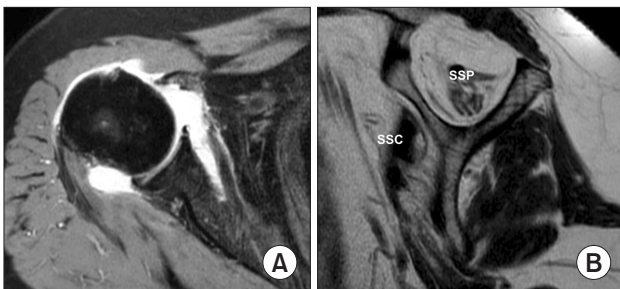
Preoperative magnetic resonance imaging (MRI) evaluation. (A) Axial T2-weighted MRI of the left shoulder displayed a torn and medially retracted subscapularis (SSC) tendon, denoted by an asterisk. (B) Sagittal oblique T1-weighted MRI showed significant fatty infiltration in both the SSC and supraspinatus (SSP) tendons.
